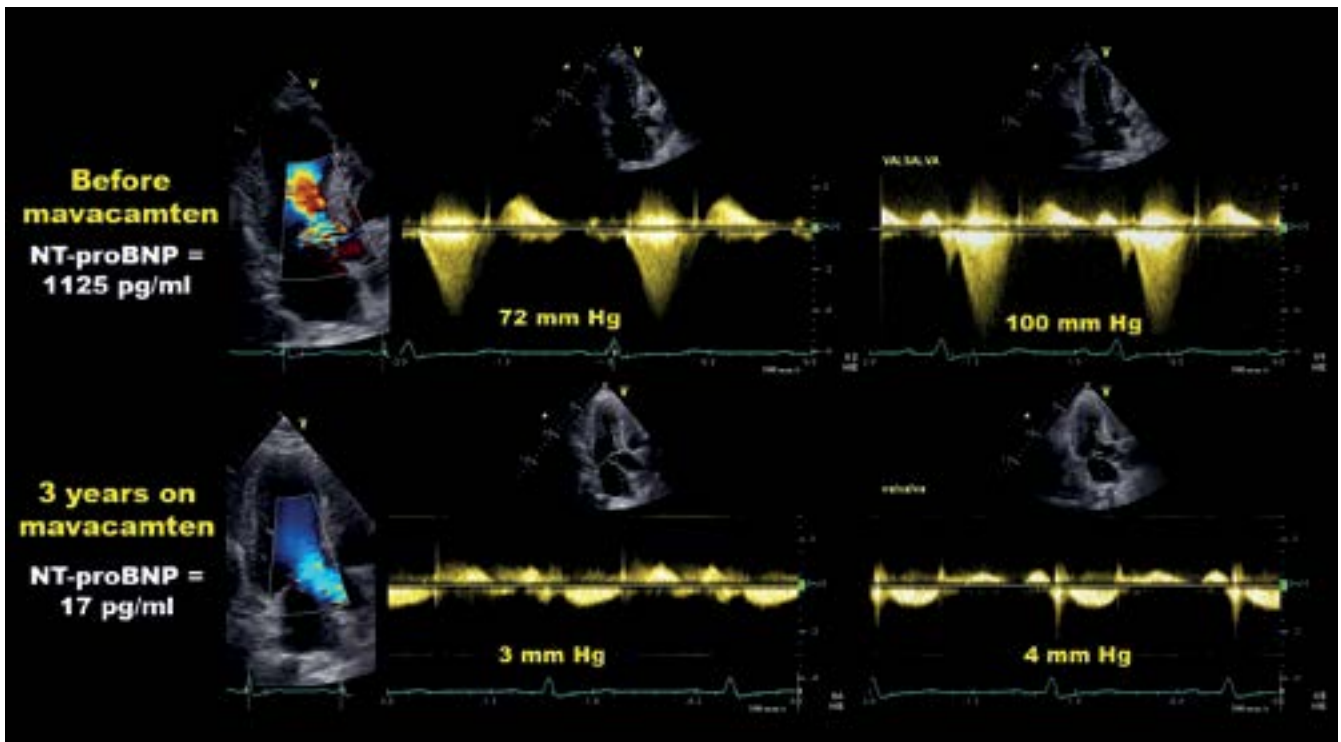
Effects of mavacamten on left ventricular outflow tract (LVOT) obstruction in obstructive hypertrophic cardiomyopathy. Upper panel: echocardiographic features at baseline in a sample subject, presenting with severe LVOT obstruction (resting 72 mmHg, Valsalva 100 mmHg) and left ventricular hypercontractility (left ventricular ejection fraction 75%). Lower panel: At the end of the third year of treatment with mavacamten, there is complete abolition of LVOT gradient (resting 3 mmHg, Valsalva 4 mmHg). N-terminal pro-B-type natriuretic peptide dropped from 1125 pg/ml at baseline to 17 pg/ml at end of follow-up
